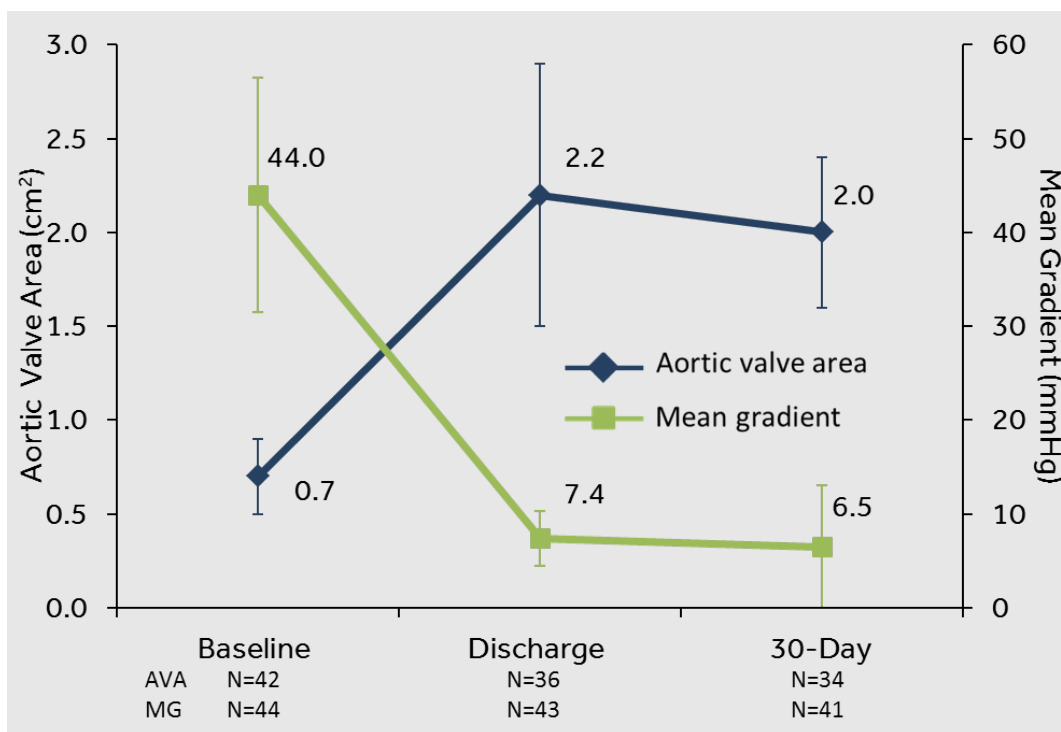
Evolut™ PRO core lab echocardiographic results: mean gradient and aortic valve area
